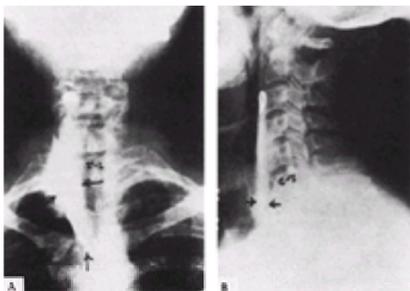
Roentgenograms showing the characteristic pattern of diffusion (*arrows*) of 10 mL of contrast medium (Diodrast) injected in the same fascial plane as the cervicothoracic sympathetic chain. A: Anteroposterior view showing the spread from the top of the C-5 vertebra (which includes the middle cervical ganglion) to the T-4 vertebra at the level of the T-4 or T-5 sympathetic ganglion. B: Lateral view. (From Moore DC. *Stellate ganglion block*. Springfield, IL: Charles C Thomas Publisher, 1954, with permission.)
